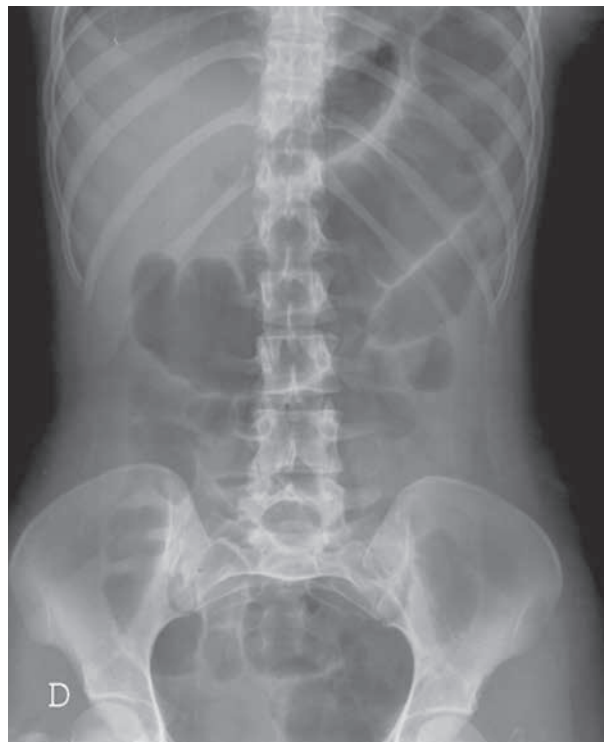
Plain abdomen x-ray showing a 7 cm colonic dilatation.
